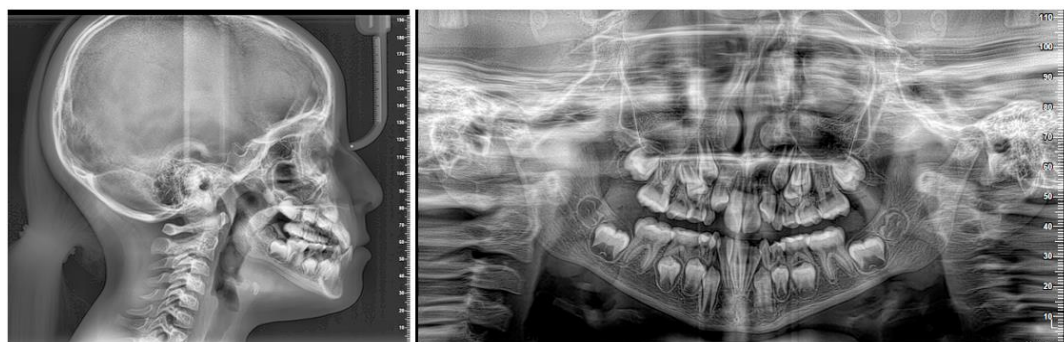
Initial radiographic records.
